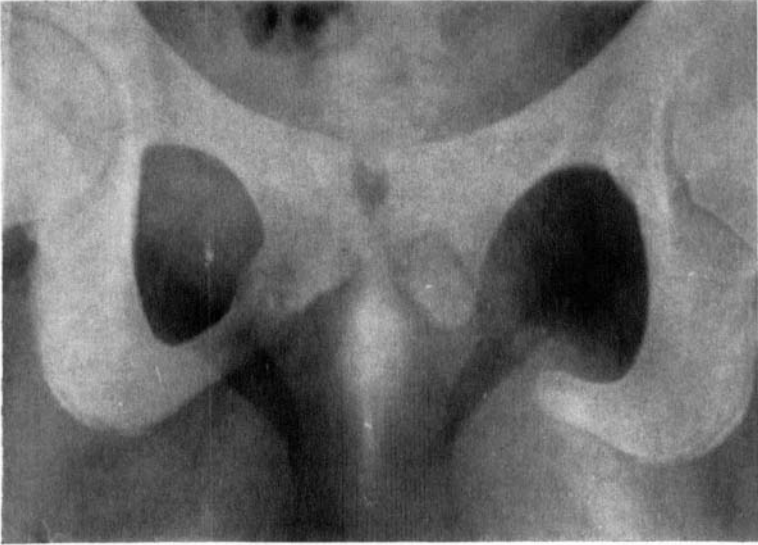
Radiograph of the pelvis in a 14-year-old girl showing ischiopubic osteochondrosis on the left. On the right a 22 mm wide gap is noticed between the bone ends of the inferior ischial ramus and the inferior pubic ramus. Check radiograph 18 months later shows unchanged conditions.
